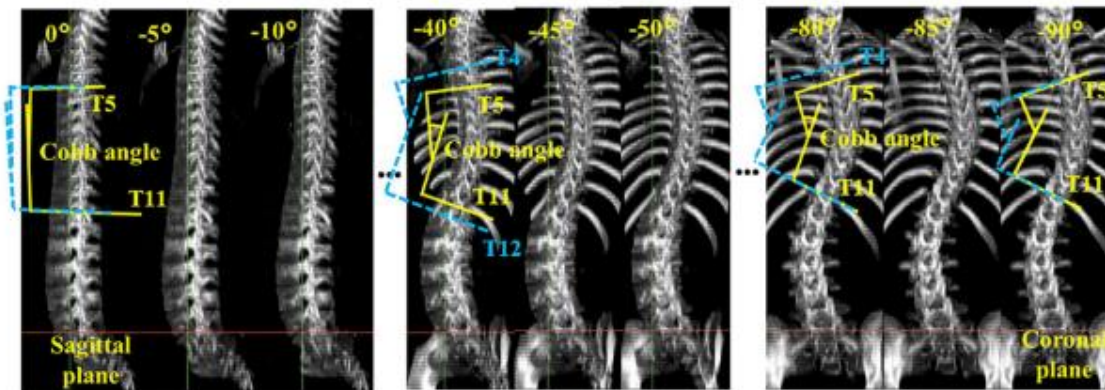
Cobb angle measured in different CT rotated images. Constrained (solid lines) and unconstrained (dashed lines) Cobb methods (the rotated planes, n=19) were generated by rotating a vertical plane 90° around axially from the sagittal to coronal plane with an increment of 5°; counter-clockwise rotation was for a right thoracic curve and recorded as negative (-)
